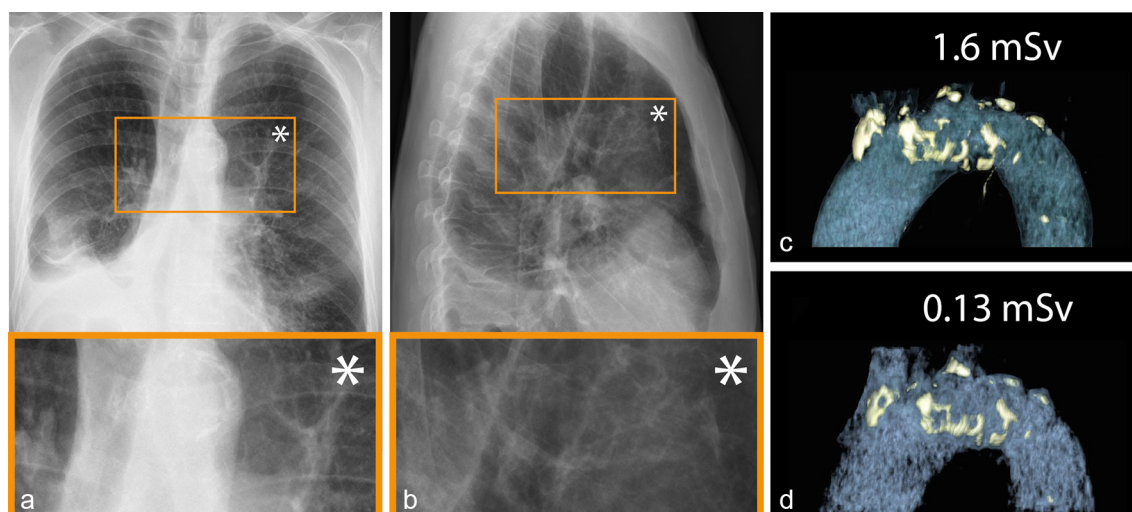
Representative posteroanterior (a) and lateral (b) chest X-rays of a 63-year-old male with a body mass index of  $21.8 \text{ kg m}^{-2}$ . Some calcifications of the aortic arch (asterisk; zoomed images) can be seen in both views of X-ray images, however 3D volume rendering images based on standard-dose CT (c) (effective dose 1.62 mSv) and ultralow-dose CT (d) (effective dose 0.13 mSv) allow for a more detailed estimation of the amount and localization of aortic calcifications.
